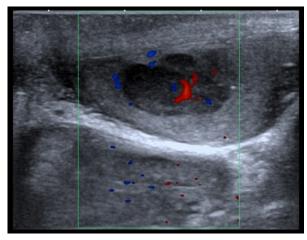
Left testicular seminoma (color doppler image).
